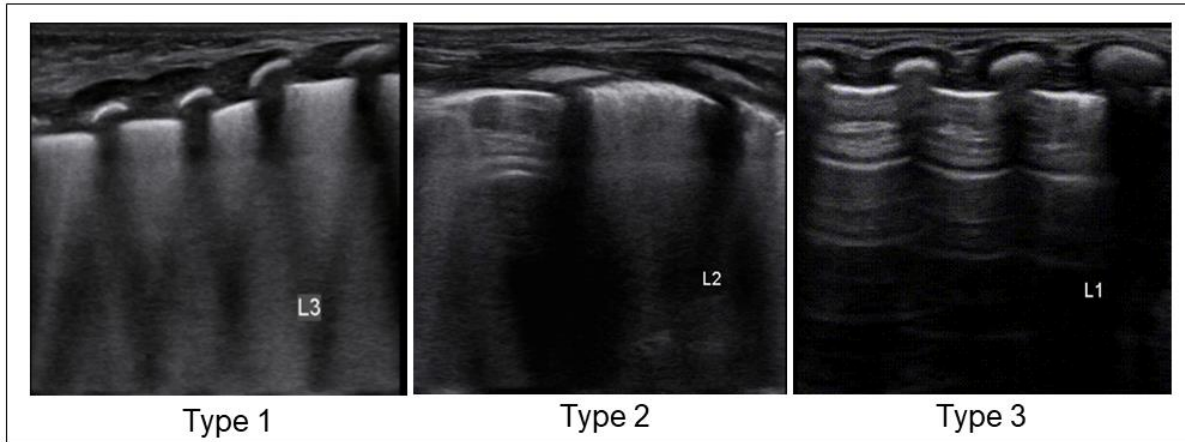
Ultrasound appearance of neonate lungs based on type: Type 1, 'white-out' lung, significant fluid retention. Type 2: partial retention of lung fluid (partial AFC). Type 3, lungs with normal aeration (complete AFC)
